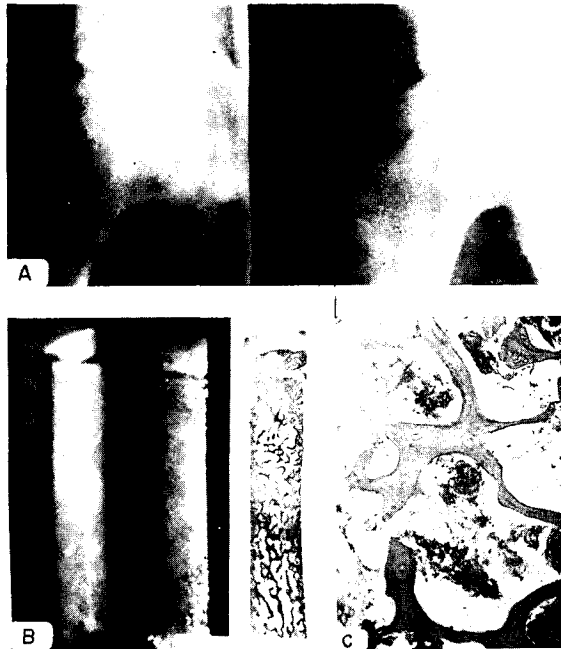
A, Radiographs, including tomogram of the right hip, show minimal collapse of the femoral head but with rather marked increase in density distally to the head-neck junction. A small subchondral cortical zone of radiolucency is also present.
